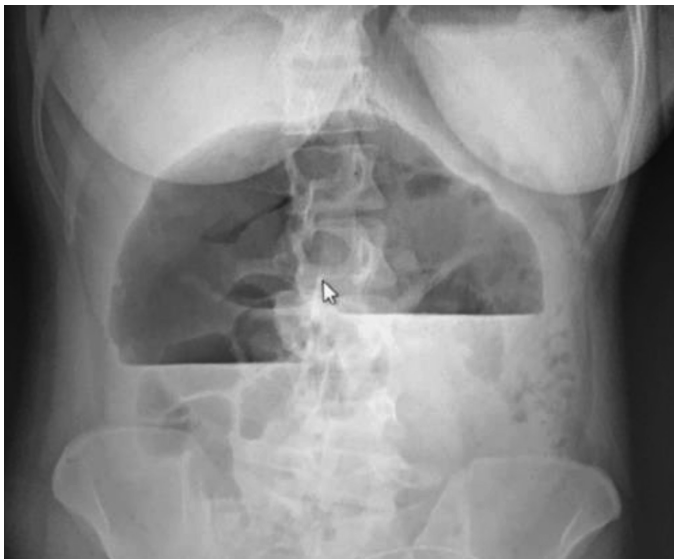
Plain radiograph shows dilated colon with gas and air fluid level at the upper right quadrant
